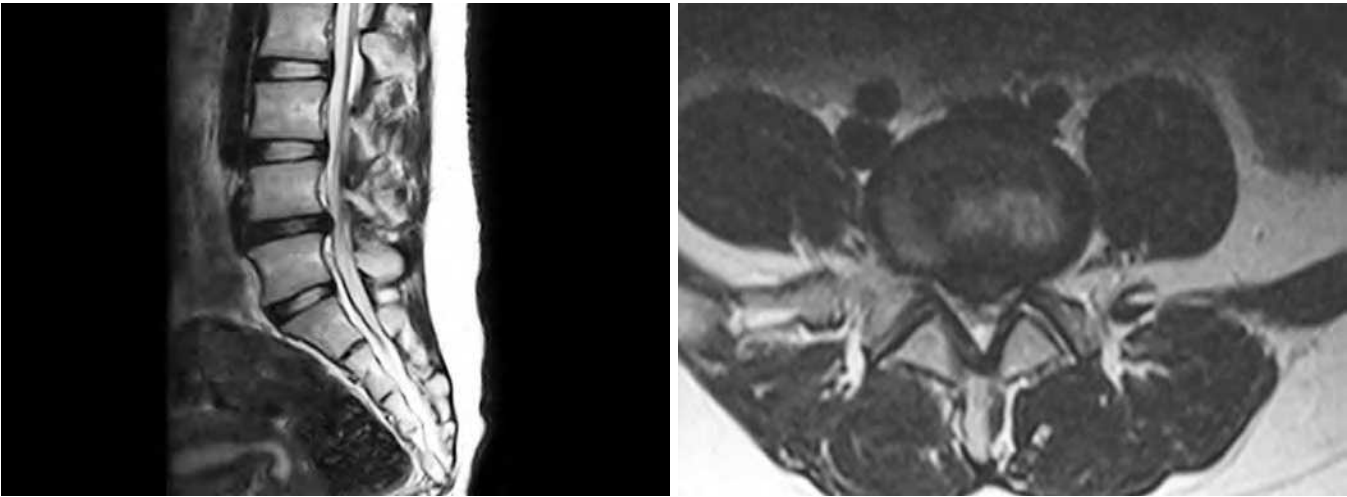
Magnetic resonance imaging of 16-year-old girl indicated L4/5 disc herniation.
